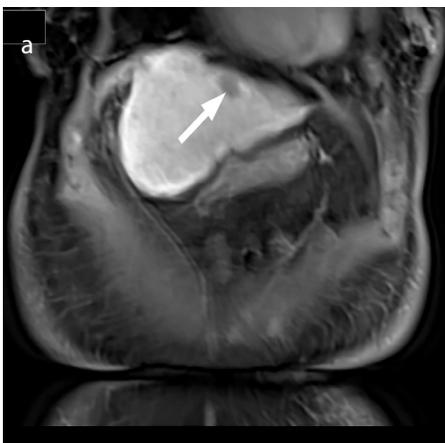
(a-c) Cardiac tamponade. Coronal fat-suppressed post-contrast T1-weighted image (a) shows a hepatocellular carcinoma (arrow) with washout in segment 2 of the liver near the pericardium. The patient became hypotensive after insertion of the radiofrequency ablation (RFA) needle and developed increased central venous pressure suggestive of cardiac tamponade. Sagittal plain computed tomography image (b) demonstrates the RFA needle's tip (arrowhead) abutting the pericardium with adjacent pericardial effusion (arrow). An 8-French pigtail catheter was immediately inserted into the pericardial space via the subcostal route. Fluoroscopic spot image (c) shows the position of the pigtail drainage catheter (arrow).
